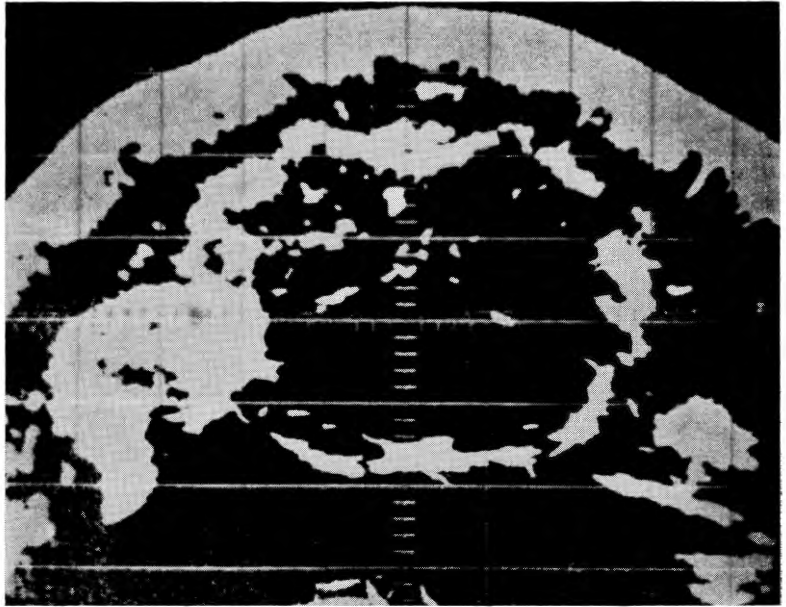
Sonogram of a pregnant woman at 34 weeks gestation. At the top is the outline of the fetal thorax with the fetal spine delineated; on the left are echo patterns probably from a fetal extremity. Reprinted from *Am. J. Obstet. Gynec.* 92: 44, 1965.
